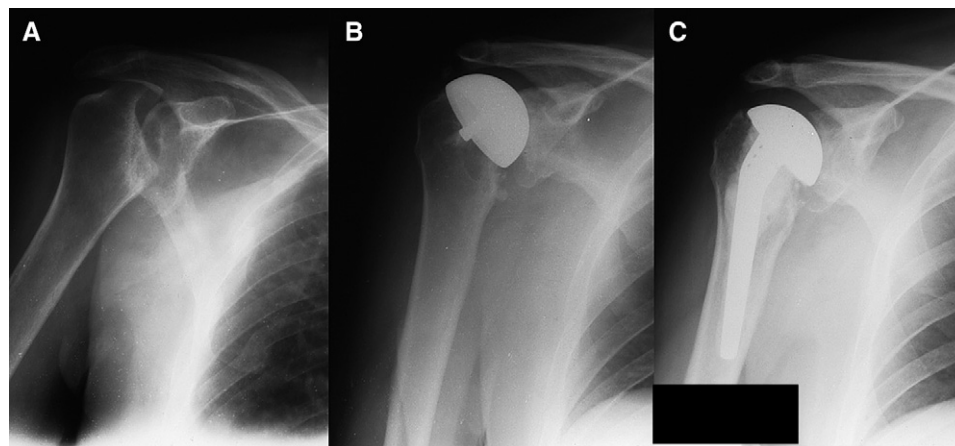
Anteroposterior shoulder radiographs. A, Preoperative image with large humeral head defect from anterior dislocation. B, Postoperative image after insertion of cemented hemi-resurfacing prosthesis. C, Postoperative image after revision of resurfacing prosthesis to cemented stem-supported humeral prosthesis.
